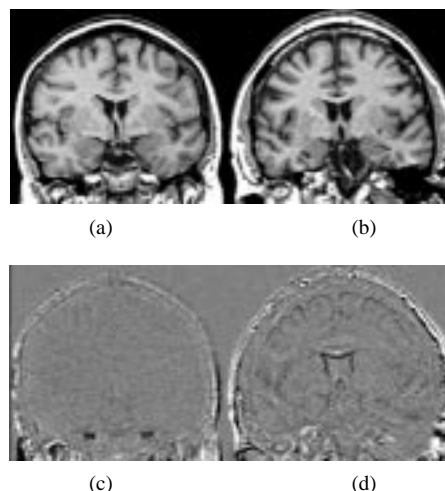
Coronal slices through T1-weighted 3D MR scans of (a) a normal control and (b) an AD patient. Repeat scans were acquired over one year later and registered to these baselines. Difference between baseline and registered repeat scans are shown in (c) and (d), respectively.
